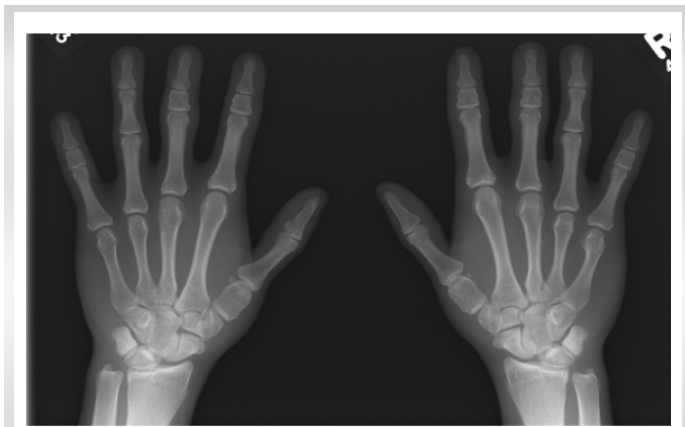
Radiograph of brachydactyly type C. Shortening of middle phalanges of the index, ring and little fingers third digits. There is also shortening of the thumb metacarpal.
